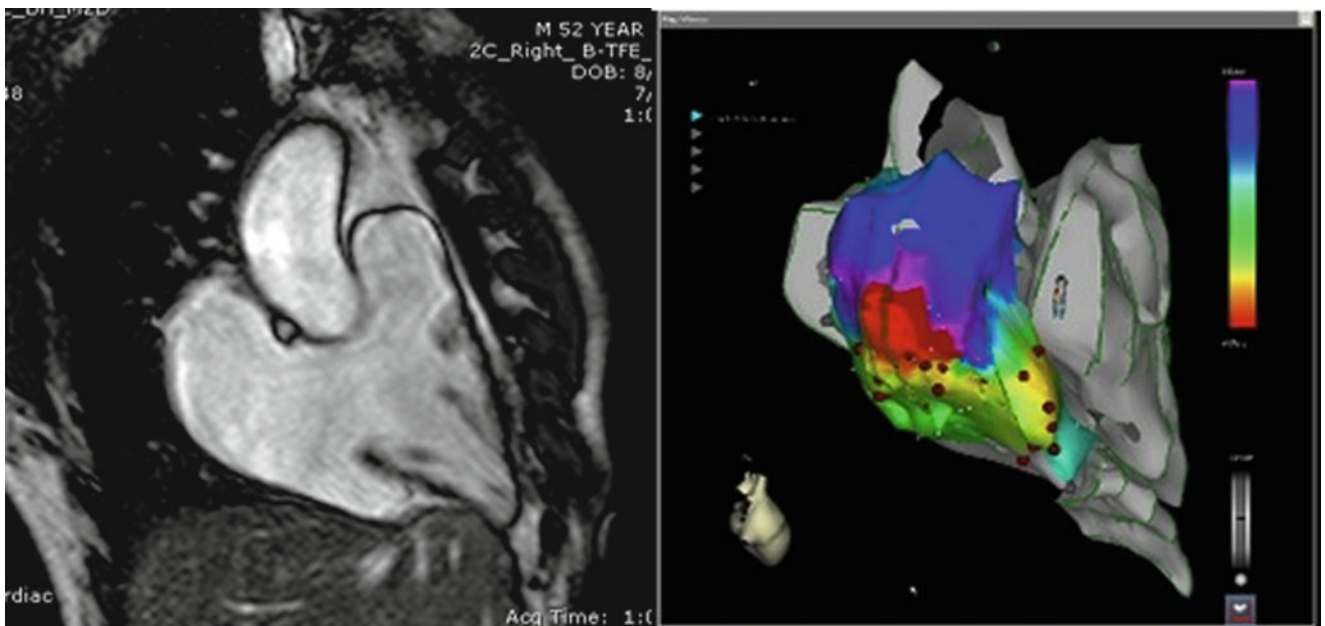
Use of CartoSOUND integration of ICE and electroanatomical navigation to construct chamber volumes for real-time mapping. On the left, an MRI plane of an adult congenital patient with complex Ebstein's anomaly and a large outpouching of the subtricuspid right
